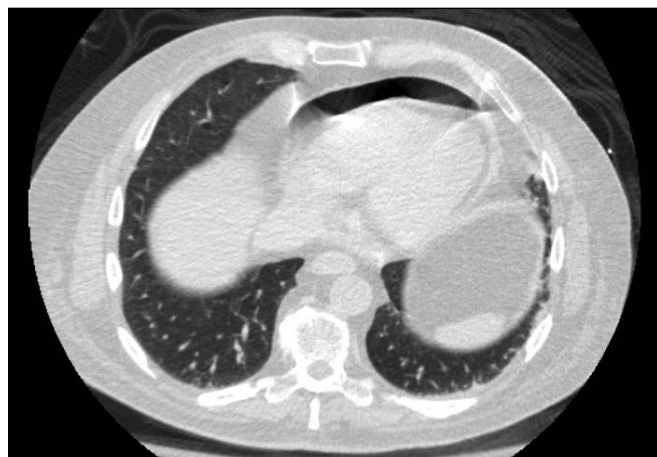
Axial CT scan of the chest with lung window showing pneumopericardium.
